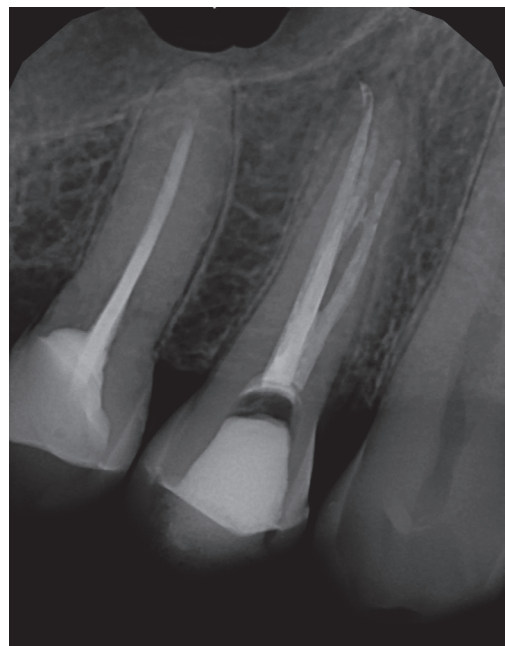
X-ray immediately after root canal filling
